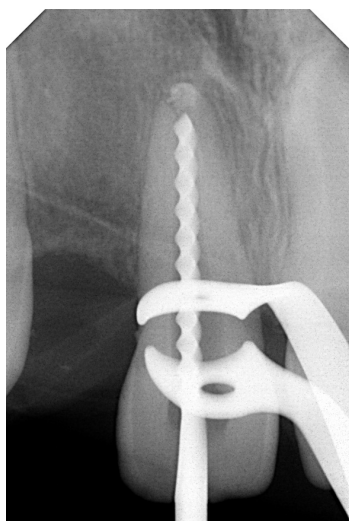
Targeted X-ray of tooth 11 during treatment (instrumental root canal treatment)
